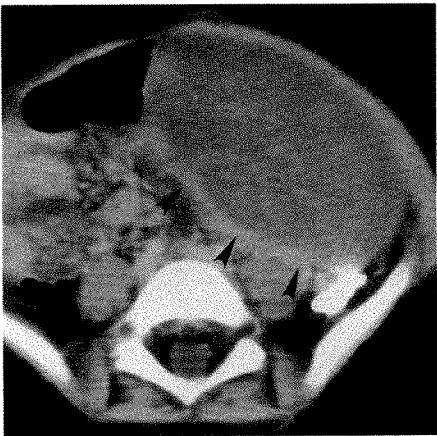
CT scan shows low-density, slightly heterogeneous spleniform mass with thick capsule (arrowheads) in left lower quadrant, displacing bowel loops to right. No splenic tissue was present on more cephalad sections. Heterogeneity within spleen reflects areas of hemorrhage within infarcted spleen.
